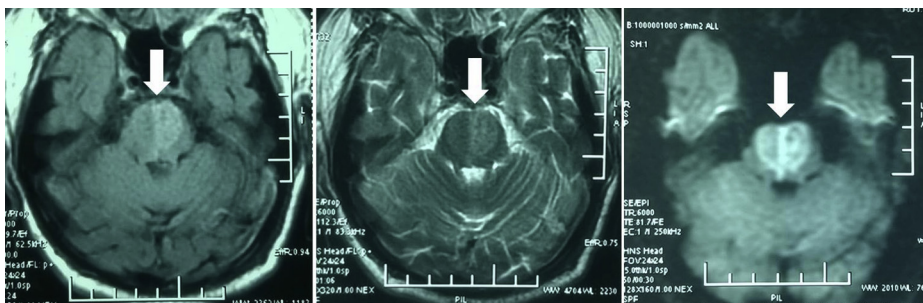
The panel of axial Flair, T2-weighted, and diffusion-weighted images shows the “heart shaped” area of hyperintensity in the pons (thick white arrows).
